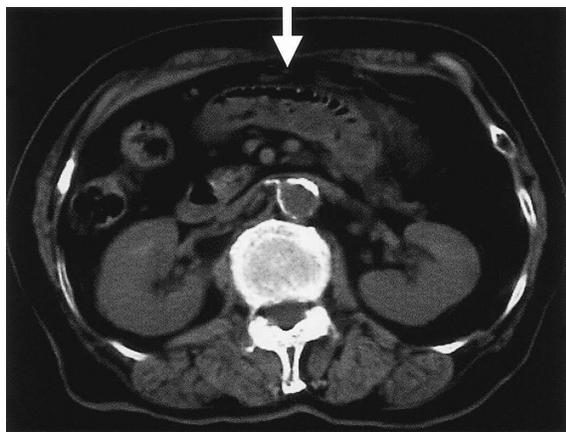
Computed tomography reveals partial distension and wall-thickening of the small intestine (arrow) without pneumoperitoneum or ascites.
